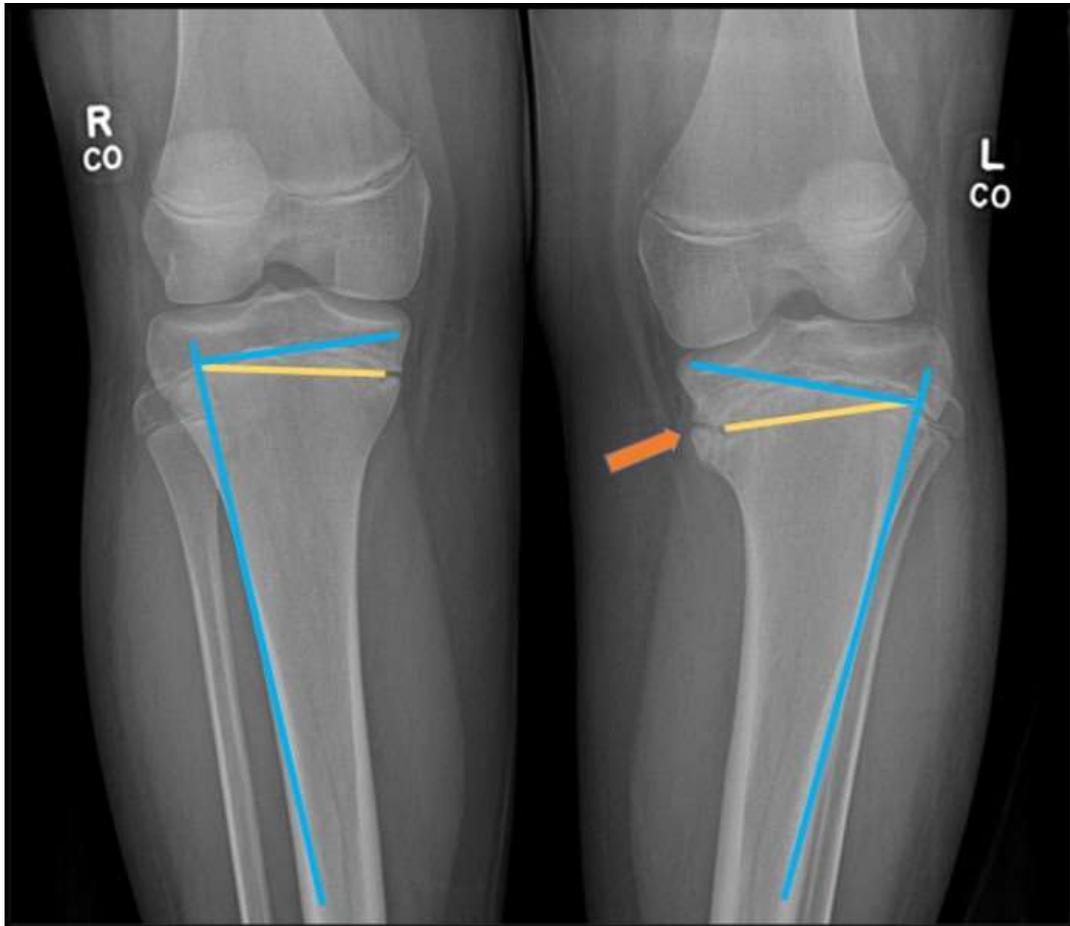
Anteroposterior radiograph of the bilateral knees of a 13-year-old male with left medial proximal tibial slope, increased metaphyseal-diaphyseal angle (MDA) and metaphyseal beaking (arrow).
